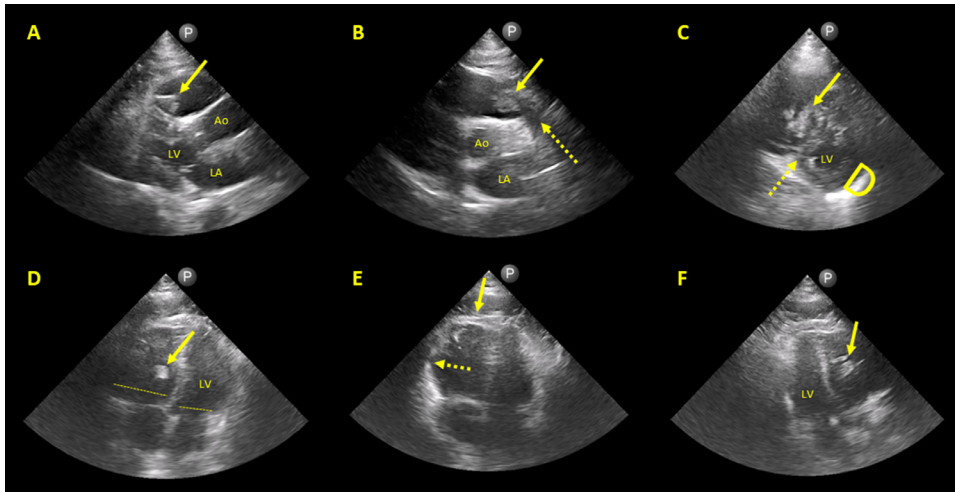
Point-of-care cardiac ultrasound showing a right ventricular thrombus in transit and echocardiographic signs of pulmonary embolism. (A) A parasternal long-axis view showing a severely dilated right ventricle with a thrombus (arrow). (B) A parasternal short-axis view at the level of great vessels showing a thrombus that is moving toward the main pulmonary artery (arrow), the dotted arrow is placed over the main pulmonary artery and points to the pulmonary valve. (C) A parasternal short-axis view at the level of the left ventricle showing a thrombus (arrow), the dotted arrow points to the interventricular septum that is flattened during systole and creates a D-shaped image, a sign of right ventricular pressure overload. (D) An apical four-chamber view shows a thrombus in the right ventricle (arrow), the dotted lines show how the right ventricle to left ventricle ratio is > 1 because of severe right ventricle dilatation. (E) An apical four-chamber view showing a severe dilated right ventricle, the arrow points to the right ventricular apex during systole with preserved contractility, while there is akinesia of the right ventricular free wall (McConnell's sign) (dotted arrow). (F) An apical long-axis view shows a thrombus in the right ventricle; note how the left ventricle appears collapsed with interventricular septum displacement due to right ventricular pressure overload.
